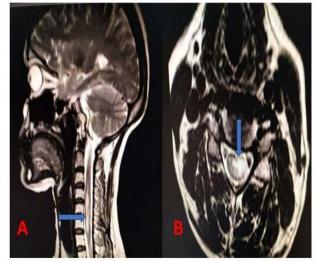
T2 sagittal spinal MRI showing long segment hyper intense signal in cervical cord indicated by horizontal blue arrow (Fig 6A). The axial T2 Images shows hyper intensity involving central spinal cord extending to left half indicated by blue vertical arrow (Fig 6B).
